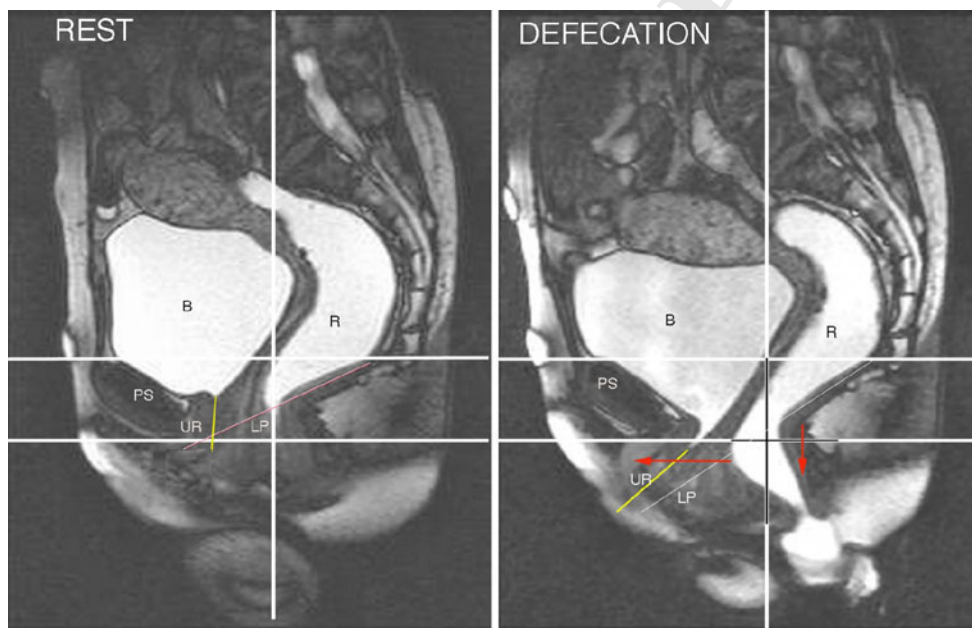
MRI constipation. *At rest* The vertical bony reference line runs through the anterior part of the space between S2 and S3. The two horizontal bony reference points run over the superior and inferior surfaces of the pubic symphysis. The anatomical course of the urethra (UR) and LP are outlined. *During defecation* Both the urethra and anterior rectal wall have been pulled forwards, altering the angle of the urethra from 92 degrees to the horizontal to 40 degrees. It is not
